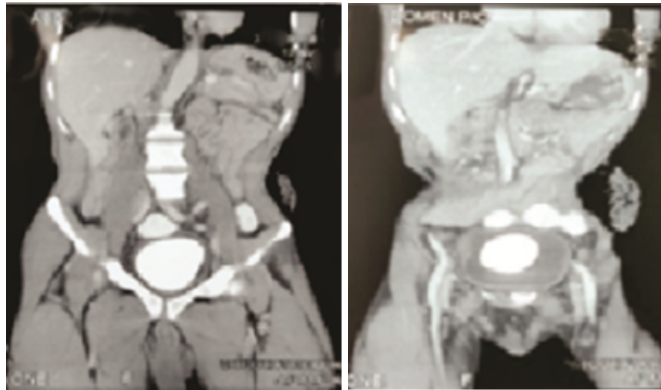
Fig-I B: CT scan showing the urinary calculus
